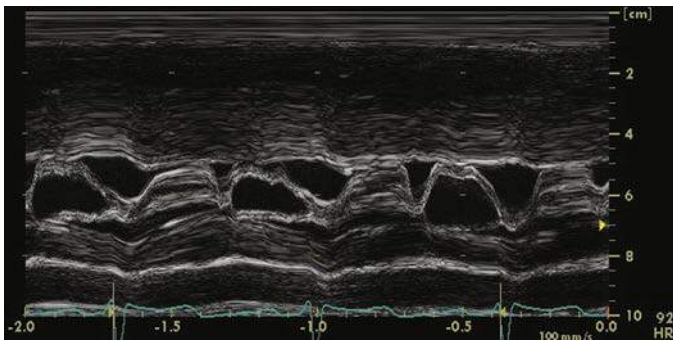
M-mode echocardiogram showing systolic anterior motion of the mitral valve in a patient with obstructive hypertrophic cardiomyopathy.
